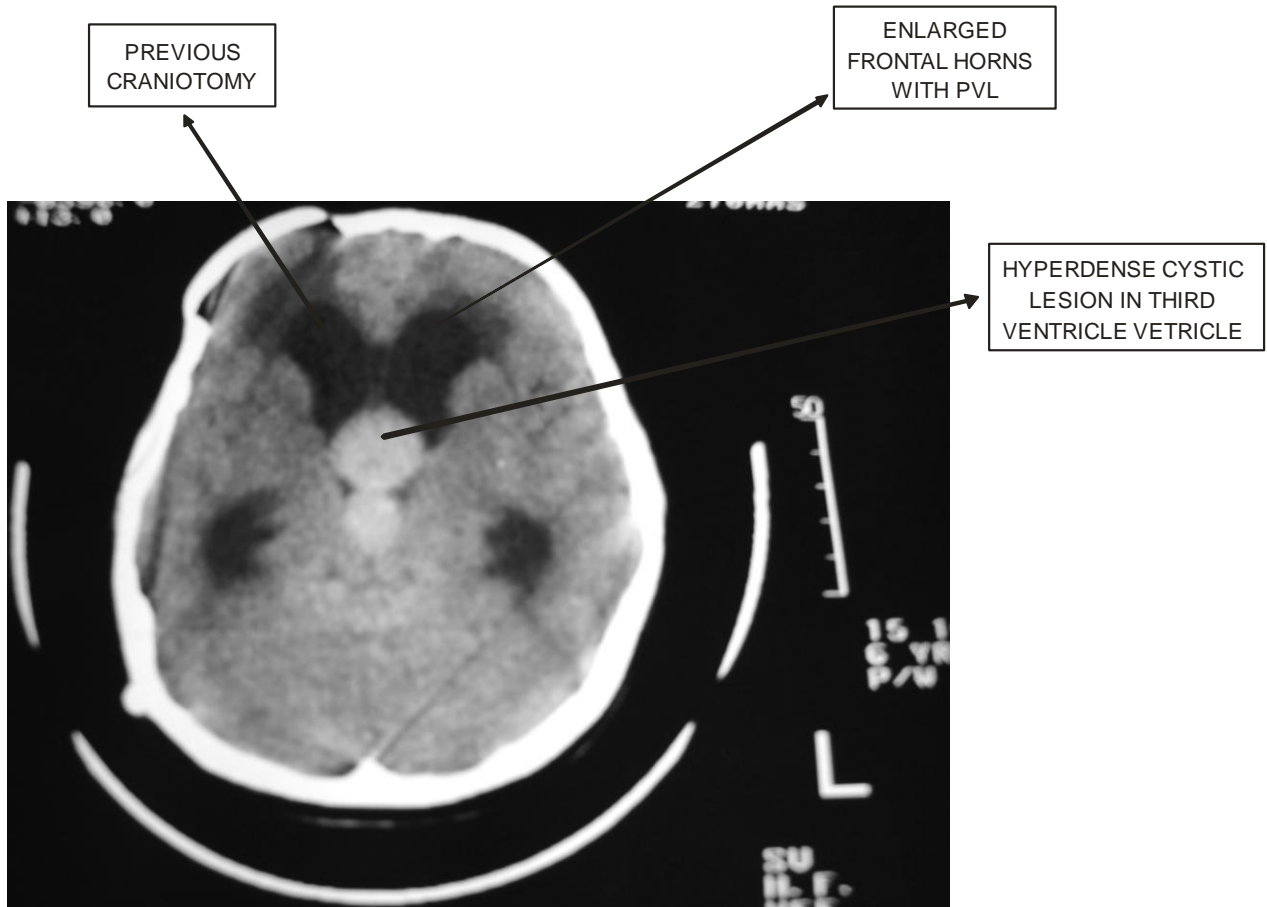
CT scan film showing hyperdense cystic craniopharyngioma in third ventricle.
